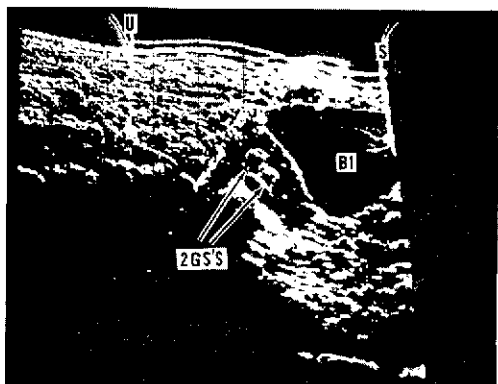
Sonograms showing growth of double-ovum twins. Top, from left: 7 weeks and 11 weeks. Bottom, from left: 17 weeks and 23 weeks. (See Figure 7 for abbreviations.)
